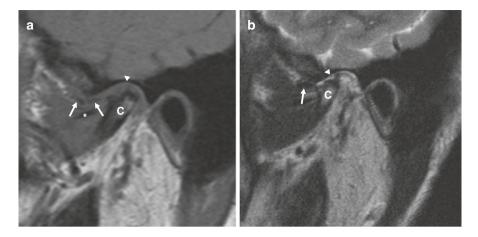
End-stage, Charcot-like destructive joint. (a) Closed-mouth sagittal image showing "broken-glass" spiculated surface of the condyle (C). There is near complete fragmentation and autolysis of the extruded disc (arrows). There is apparent discontinuity of the temporal posterior attachment (arrowhead). Chronic thickening of the lateral pterygoid fascia is apparent (asterisk). (b) Open-mouth sagittal image employing a T2-weighted pulse sequence showing a single joint space (arrow) that is compatible with an MR-arthrographic demonstration of posterior disc attachment perforation or detachment. Spiculation of the articulating surface of the condyle (C) and tubercle is demonstrated. The disc (arrows) is anteriorly displaced and deformed
